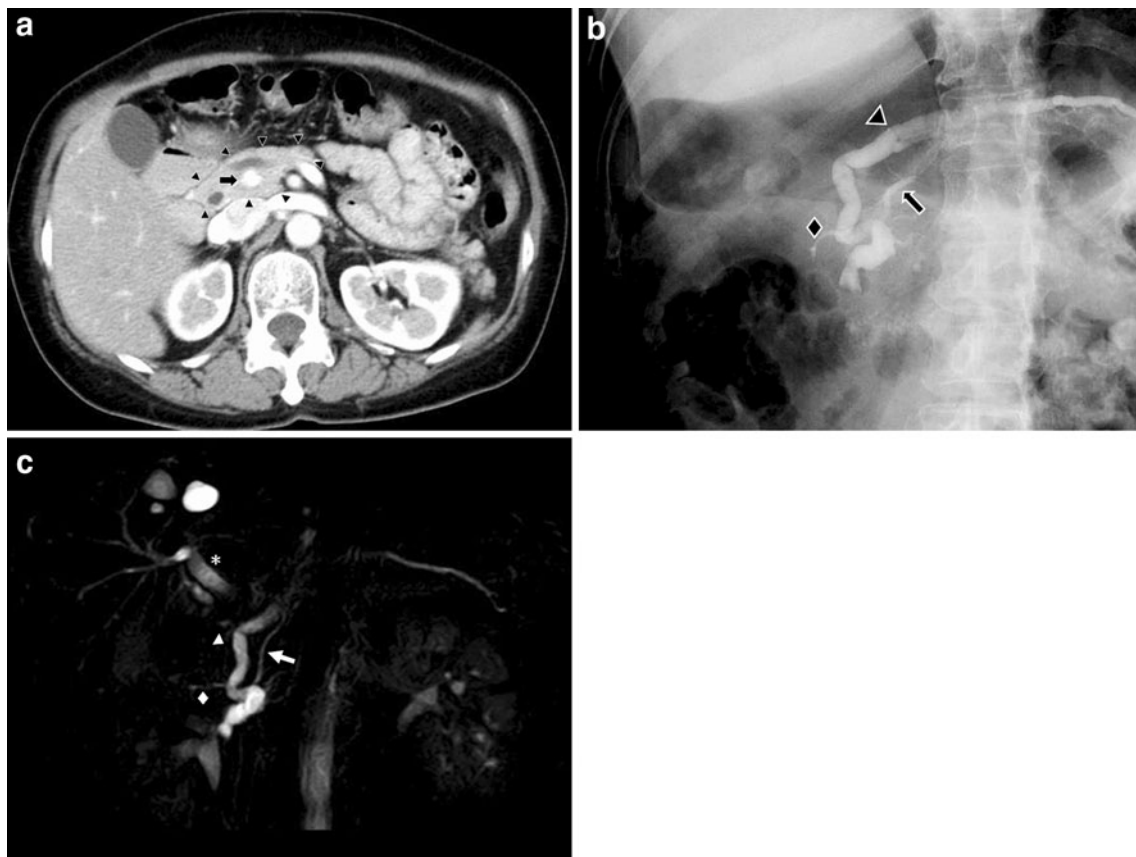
Preoperative findings of a portal annular pancreas by computed tomography and endoscopic retrograde pancreatography. CT shows the portal vein (*arrow*) is surrounded annularly by pancreatic parenchyma (*arrow heads*; Fig. 1a). Endoscopic retrograde
